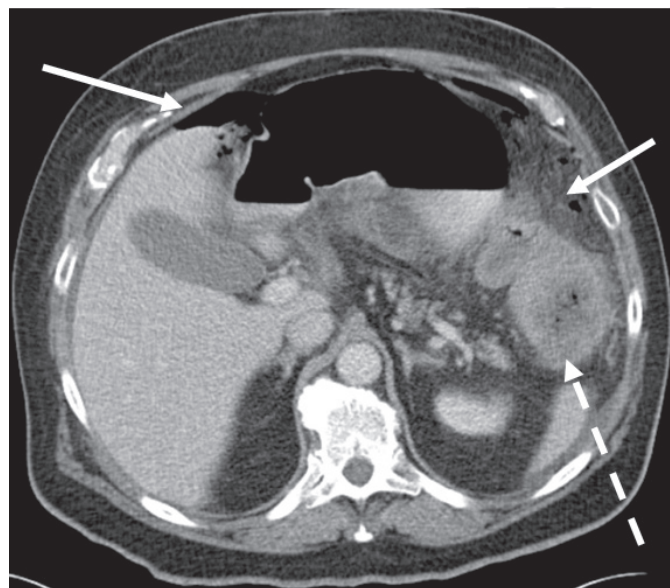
Computed tomography scan demonstrating multiple locules of free air (solid arrows) and an obstructing colonic mass at the splenic flexure (broken arrow).
